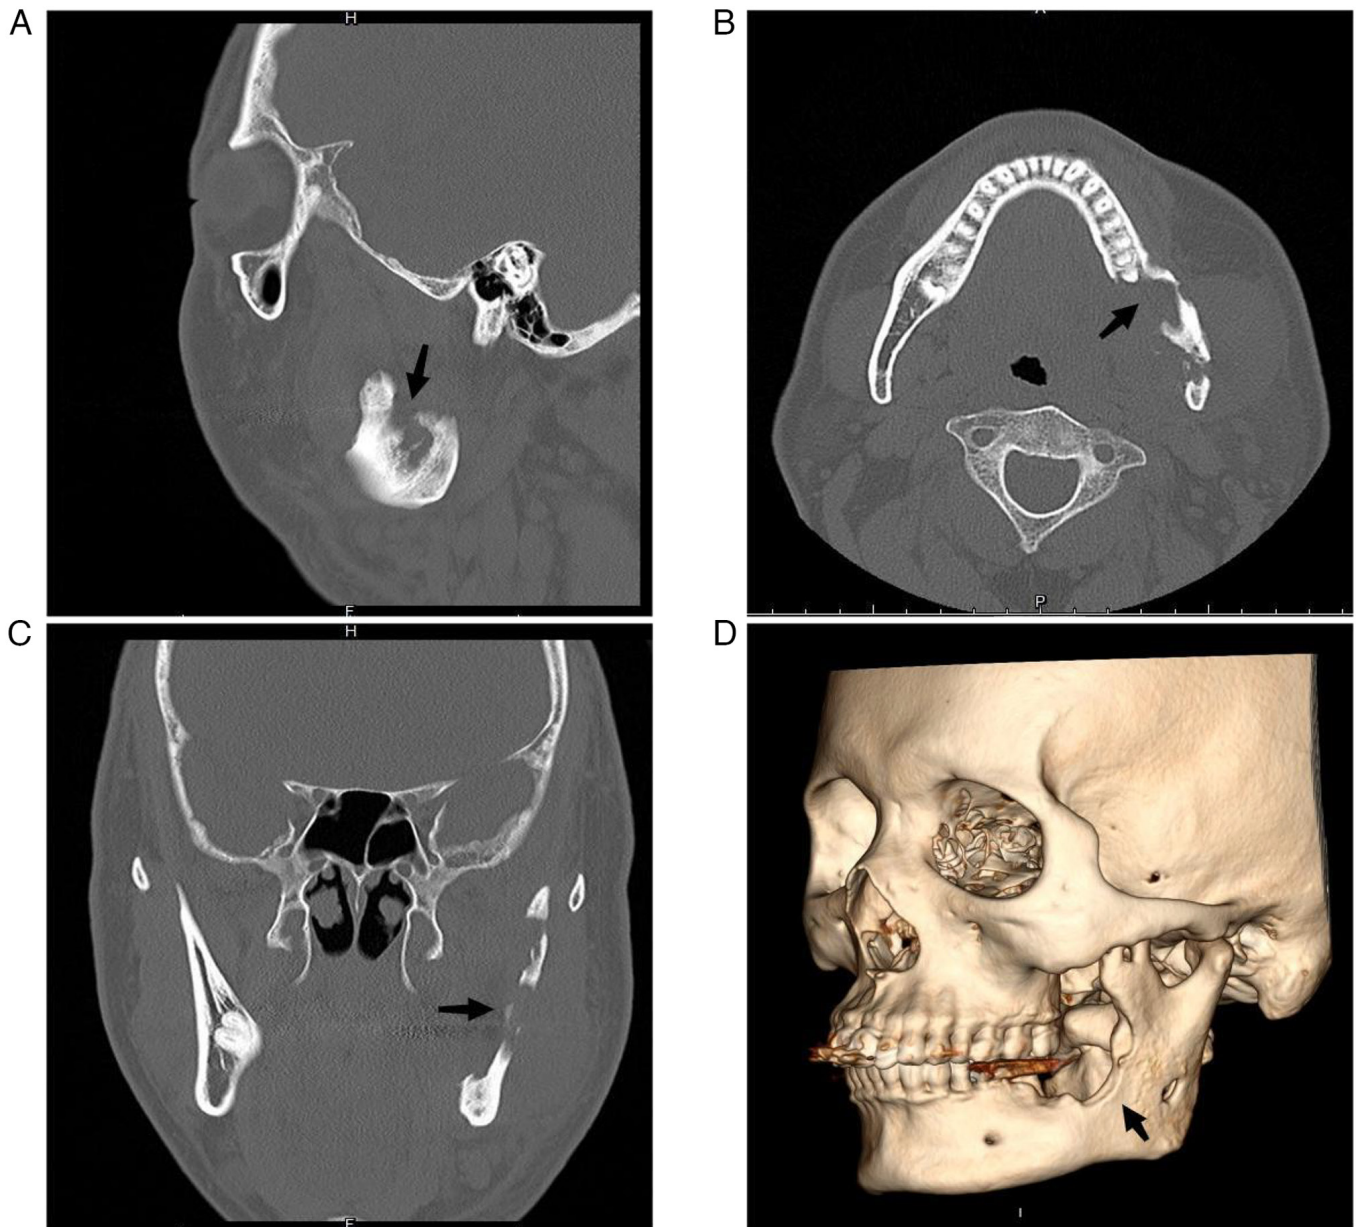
Mandibular CT scan prior to admission. (A) Sagittal view. Mandibular CT scan showed involvement of the left mandibular coronal process and ascending mandibular rami (black arrow). (B) Cross-sectional visual field. Mandibular CT scan revealed a local lamellar periosteal reaction with an increase in bone mineral density in unaffected areas (black arrow). (C) Coronal visual field. Mandibular CT scan showed significant destruction of the left ascending branch of the jaw with a soft tissue mass (black arrow). (D) 3D surface reconstruction (left maxillary surface) highlights the deformation of the left mandibular coronal process, rami and body (black arrow).
